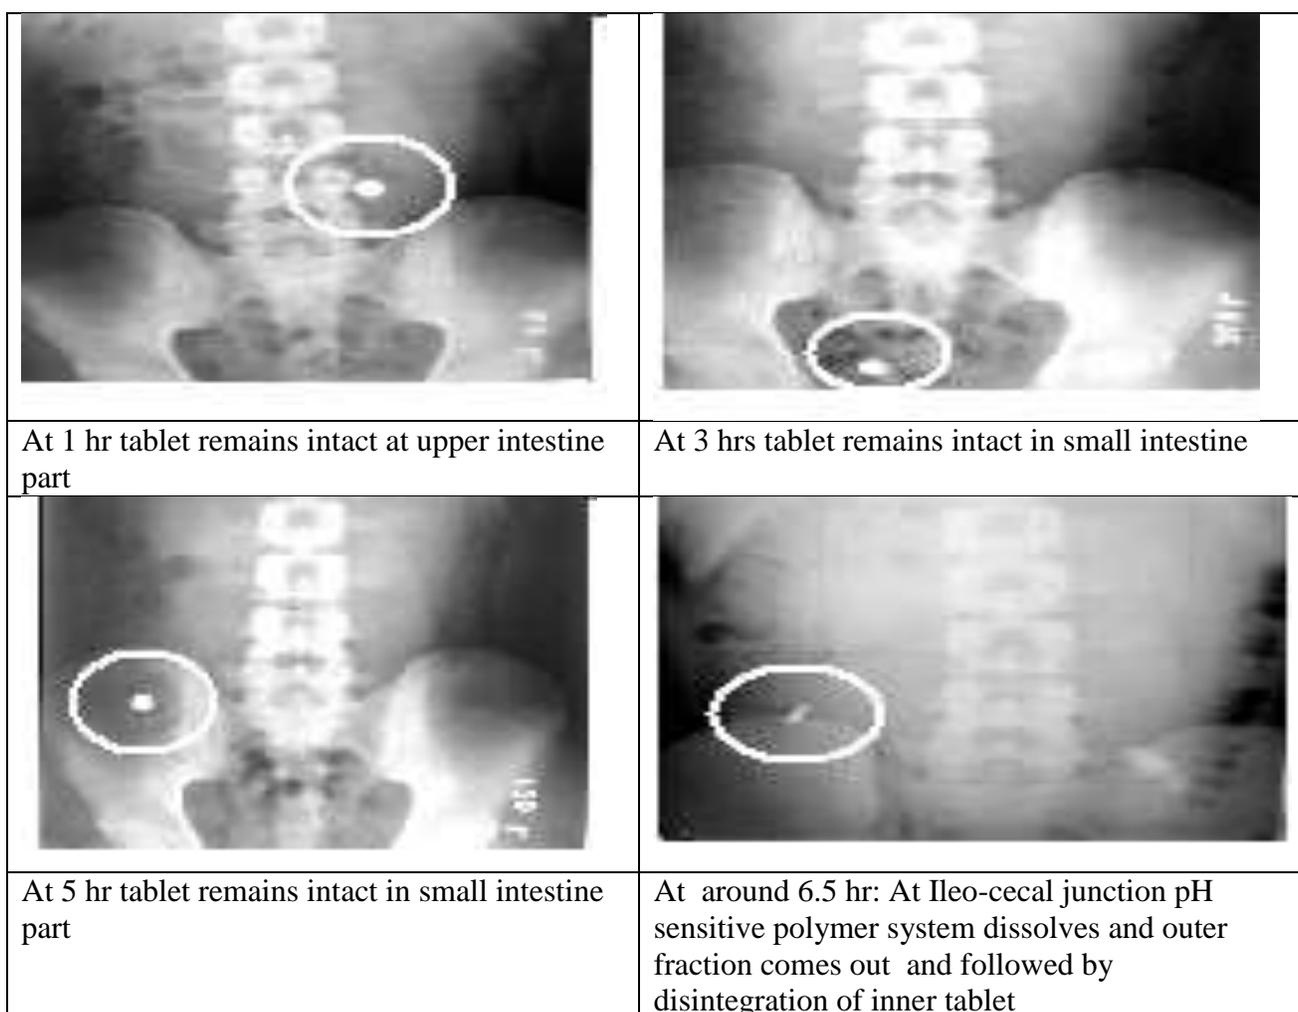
X-ray photographs to study the lag phase
